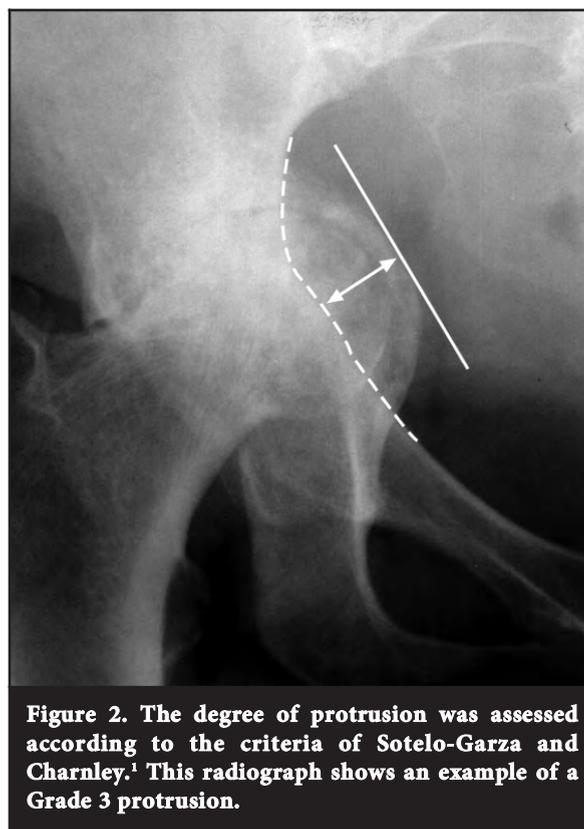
The degree of protrusion was assessed according to the criteria of Sotelo-Garza and Charnley.¹ This radiograph shows an example of a Grade 3 protrusion.
